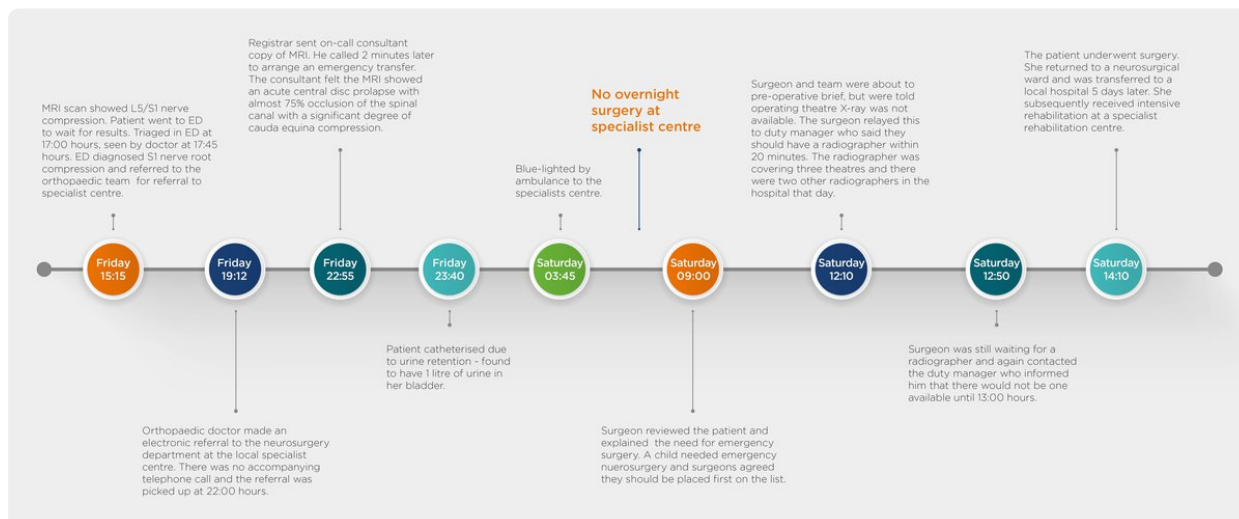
Timeline of the events affecting the Patient from MRI to surgery
